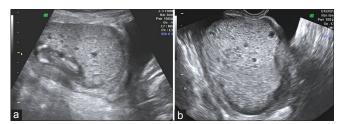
(a) Sonographic image is showing partial mole with a fetus at 12 weeks. (b) Sonographic image showing placenta with the multiple cystic spaces
